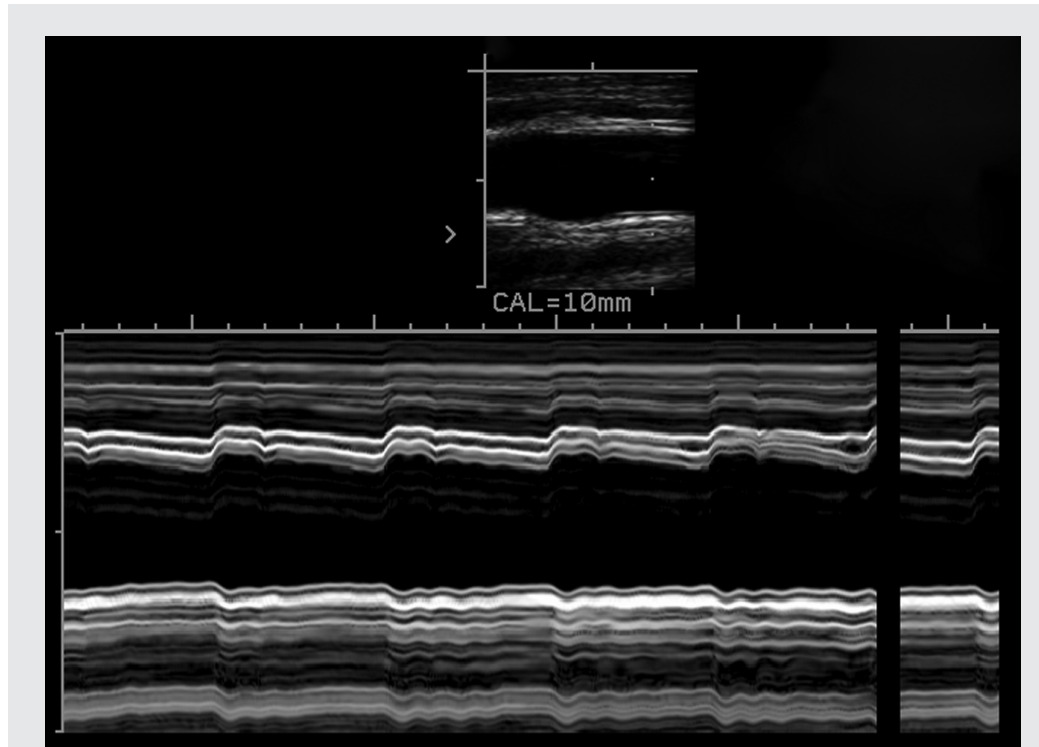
M-mode ultrasonography for measuring carotid distensibility coefficient
